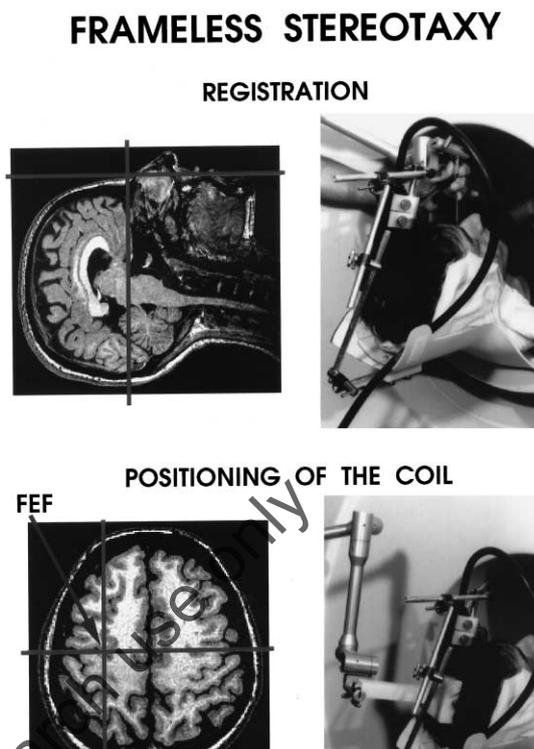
The top of the figure depicts the process of registering the subject's head with the corresponding magnetic-resonance (MR) image. A computer-linked probe is touching the bridge of the nose (right); the matching location is highlighted by a cross-hair on the MR image (left). The bottom of the figure shows a location targeted by TMS in one of our studies, namely the left frontal eye-field, FEF (left), and the probe-coil interface used to position the coil over this location (right). (1) Arm of the frameless-stereotaxy unit; (2) probe inside the interface; (3) coil inside the interface. Reprinted with permission from *Journal of Neuroscience* 1997;17:3178–84 [25].
